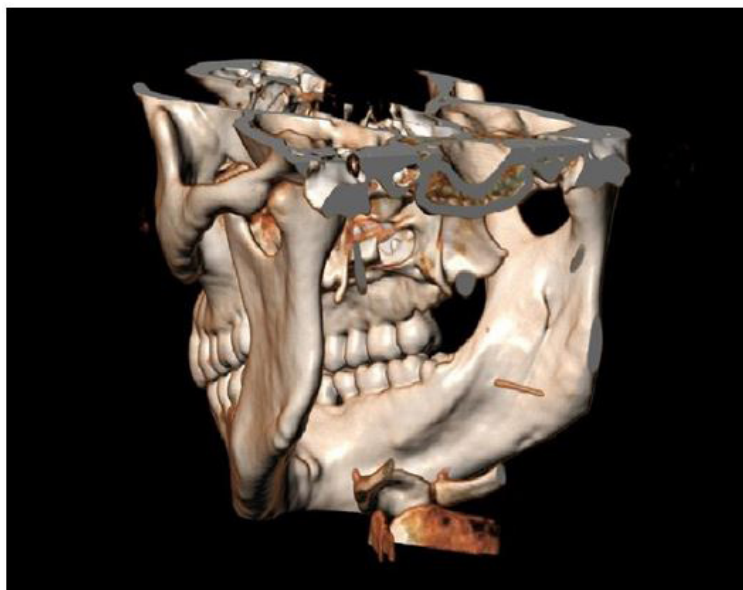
CT-SCAN 3D reconstructions, showing the position of the fragment in the right pterygo-mandibular space
